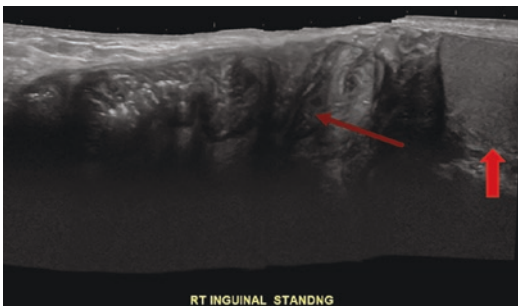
Extended field of view longitudinal ultrasound image depicting a small bowel containing indirect inguinal hernia while the patient is in the standing position. The larger arrow identifies the testicle while the diagonal arrow identifies herniated small bowel
